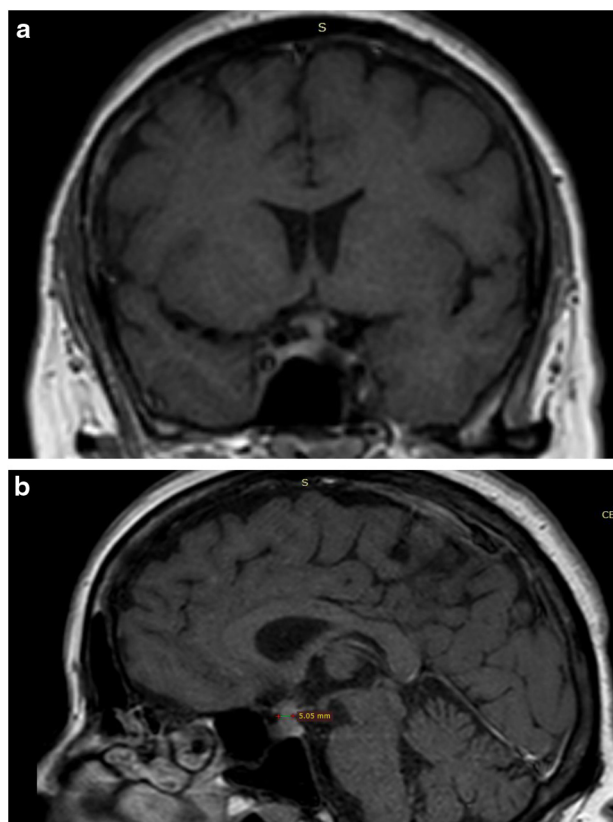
Pituitary MRI with gadolinium contrast, showing a thickened pituitary stalk measured at 5.05 mm in the sagittal T1 W image.
